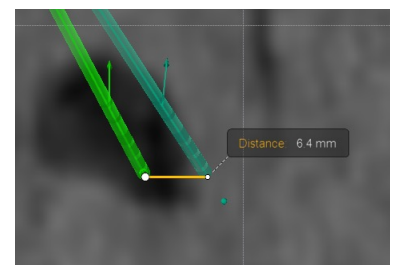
displacement on coronal MRI T1 weighted image (BrainLab)
